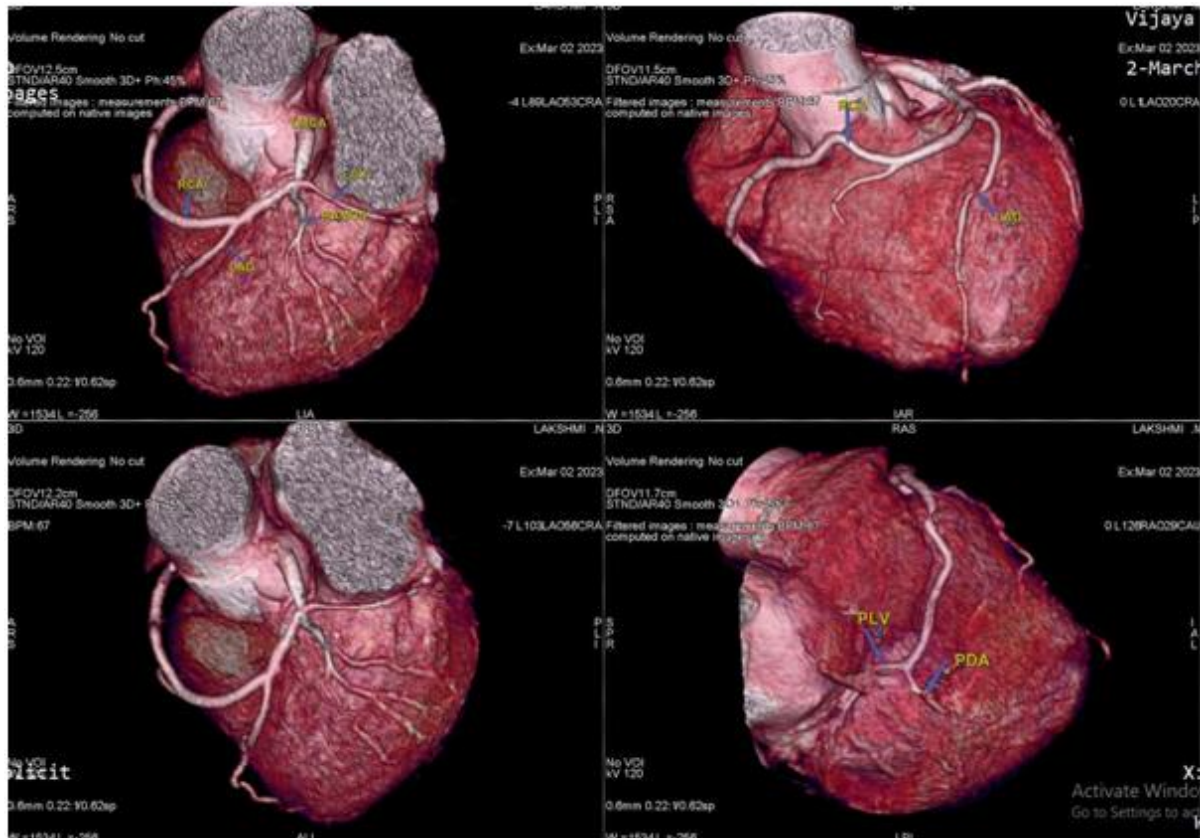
CT CAG showing Right coronary artery (RCA) arising from Left anterior descending artery (LAD) crossing to the right side anterior to right ventricular outflow tract and extending into atrioventricular groove.
